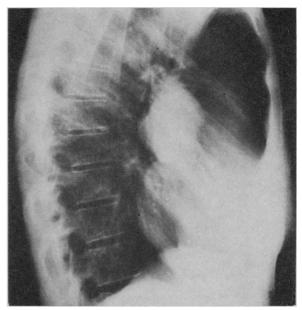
Right lateral chest roentgenogram.
